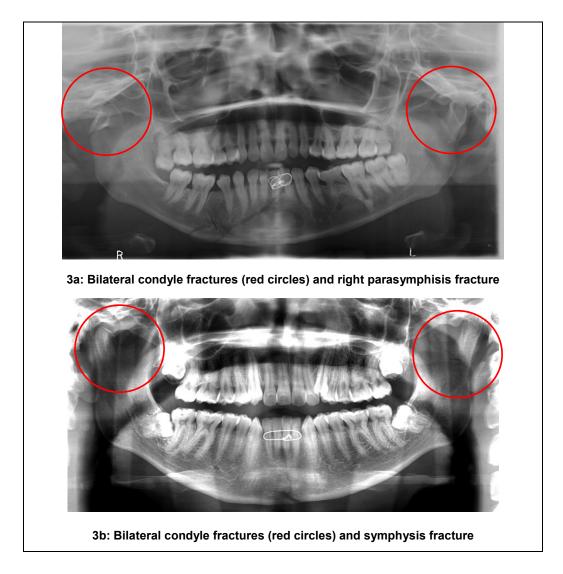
OPG radiographs showing bilateral condyle fractures
